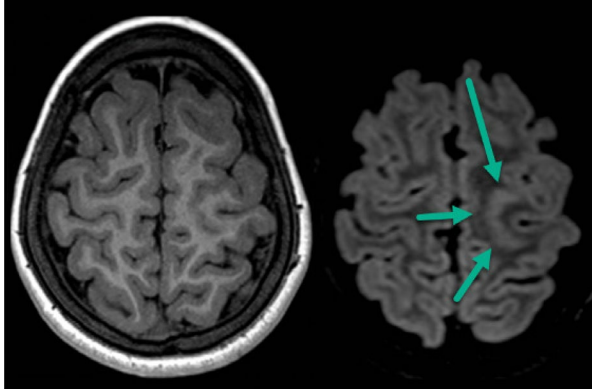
3D multiplanar reconstruction of T1 (left) and FLAIR (right) MRI sequences demonstrate left-sided focal cortical folding abnormality (arrows).
